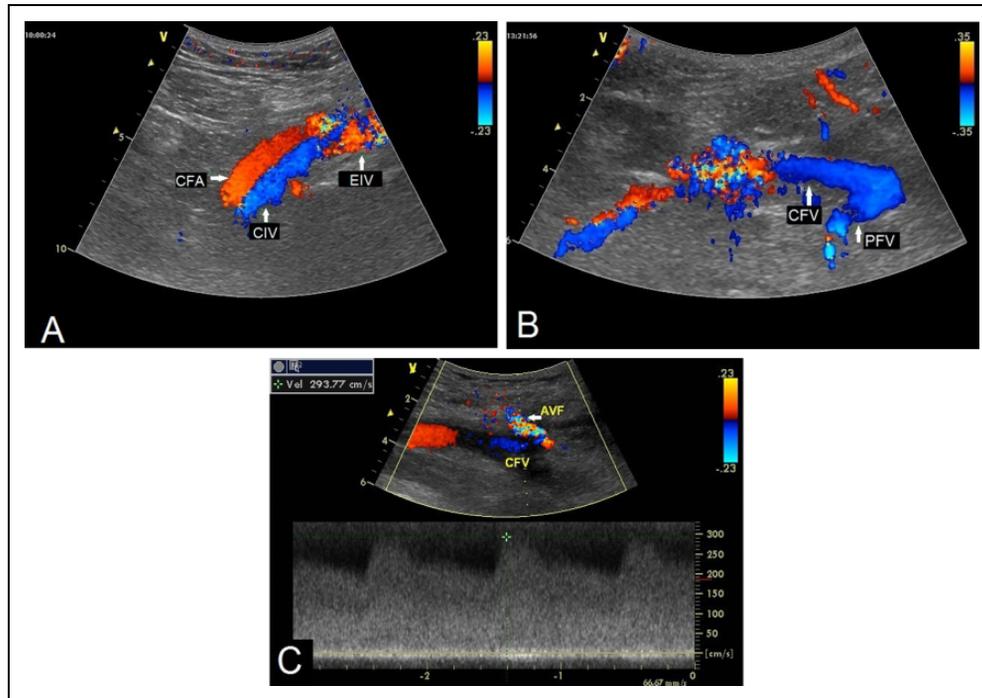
Ultrasound images of the same patient 1 month after the intervention. A and B, CIV, EIV, and PFV are patent (arrow). C, Ultrasound image of well-functioning AVF (arrow). AVF indicates arteriovenous fistula; CIA, common iliac artery; CIV, common iliac vein; EIV, external iliac vein; PFV, profunda femoris vein.
